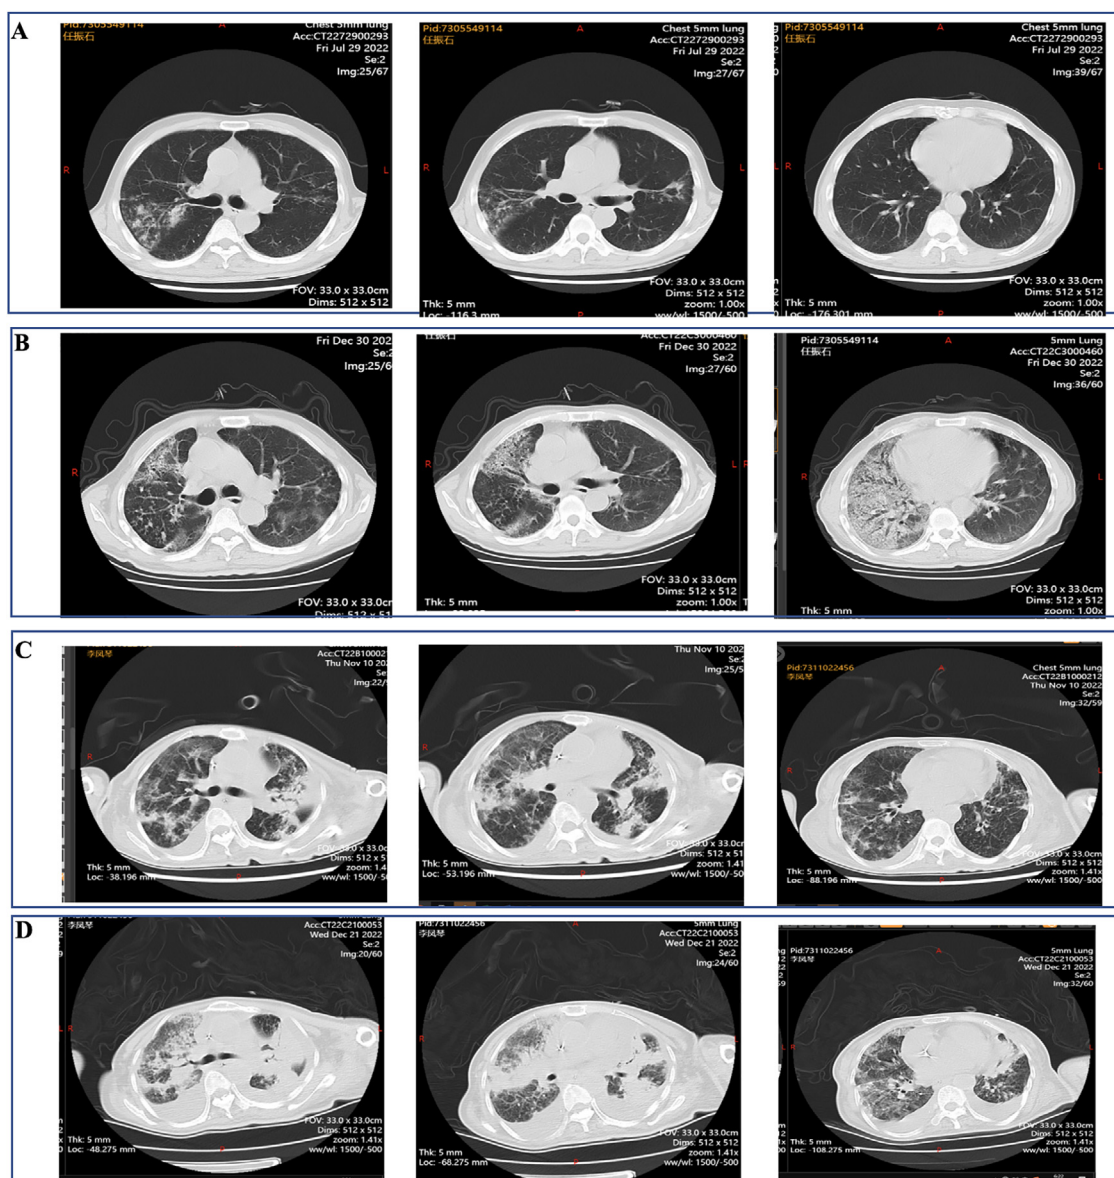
(A) Chest CT images of two patients with COVID-19-TB in Beijing, China, from 1 December 2022 to 18 January 2023. Transverse chest CT images from a 68-year-old male with TB showing the tree-in-bud sign and small cavitations before COVID-19 infection. (B) On day 14 after COVID-19 infection, the CT images show bilateral multiple lobular and subsegmental areas of consolidation. (C) Transverse chest CT images from a 63-year-old female with TB showing extensive segmental consolidation and centrilobular nodules before COVID-19 infection. (D) On day 14 after COVID-19 infection, the CT images show bilateral multiple lobular and subsegmental areas of consolidation and pleural effusion.
